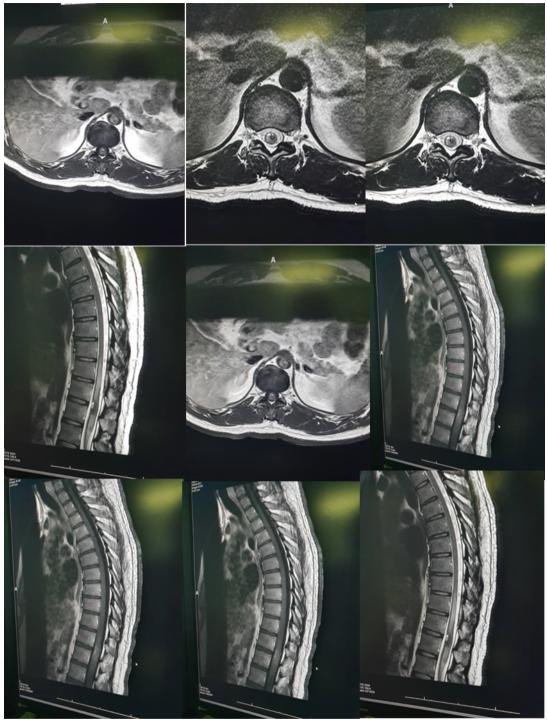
MRI diagnostic results of the spinal cord
